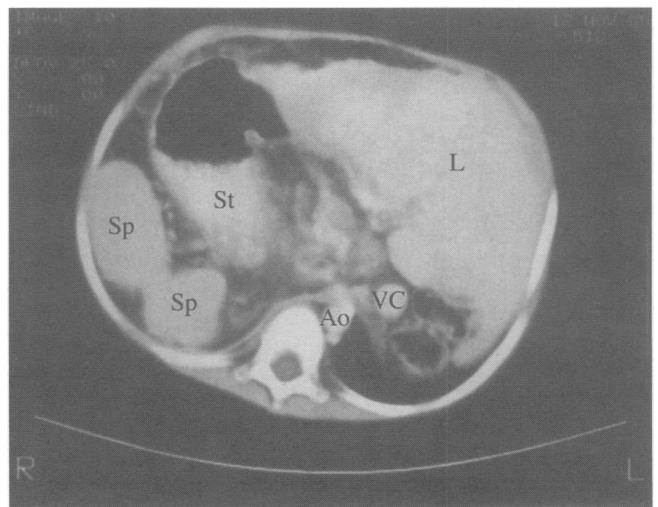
Abdominal computed tomography scan of patient No. 2 with situs inversus. The liver (L) is on the left, the vena cava (VC) is to the left of the aorta (Ao), and the spleens (Sp) and stomach (St) are on the right.
